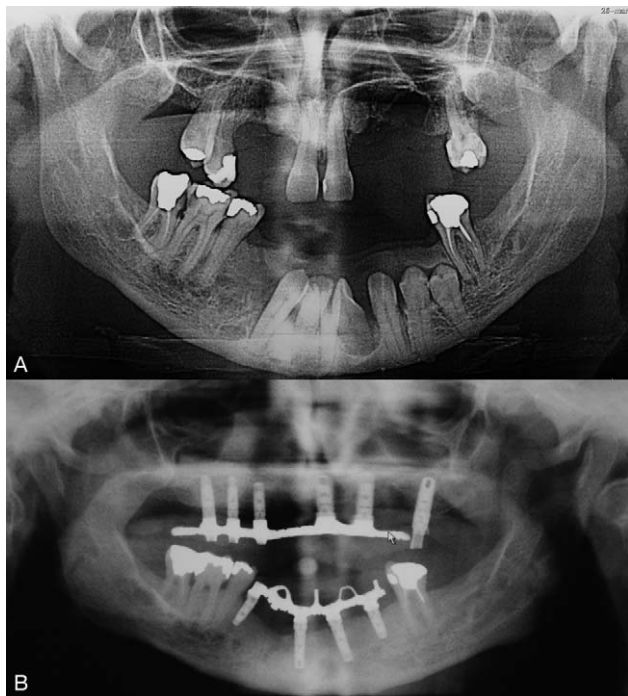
Case 7. (A) Initial panoramic x-ray showing unerupted teeth in the mandible with cystic complication. (B) Postoperative panoramic x-ray showing the implant borne denture in both jaws.
